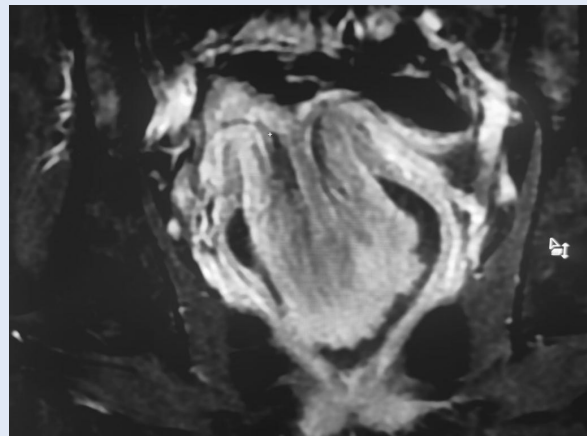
Magnetic resonance image — the bottom of the uterus pulled into the cavity by a tumor
